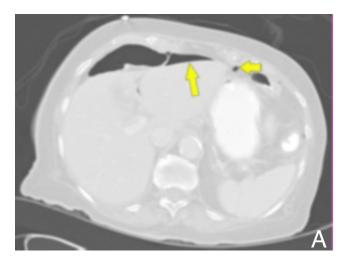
A. Axial CT with lung window settings of the upper abdomen showing free intraperitoneal air (arrows). B. Axial contrast-enhanced CT image after percutaneous drainage with drainage catheter within the mass.
